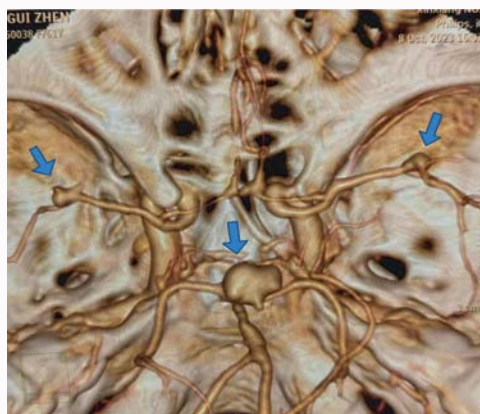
Preoperative CTA, arrow pointing to aneurysm.
